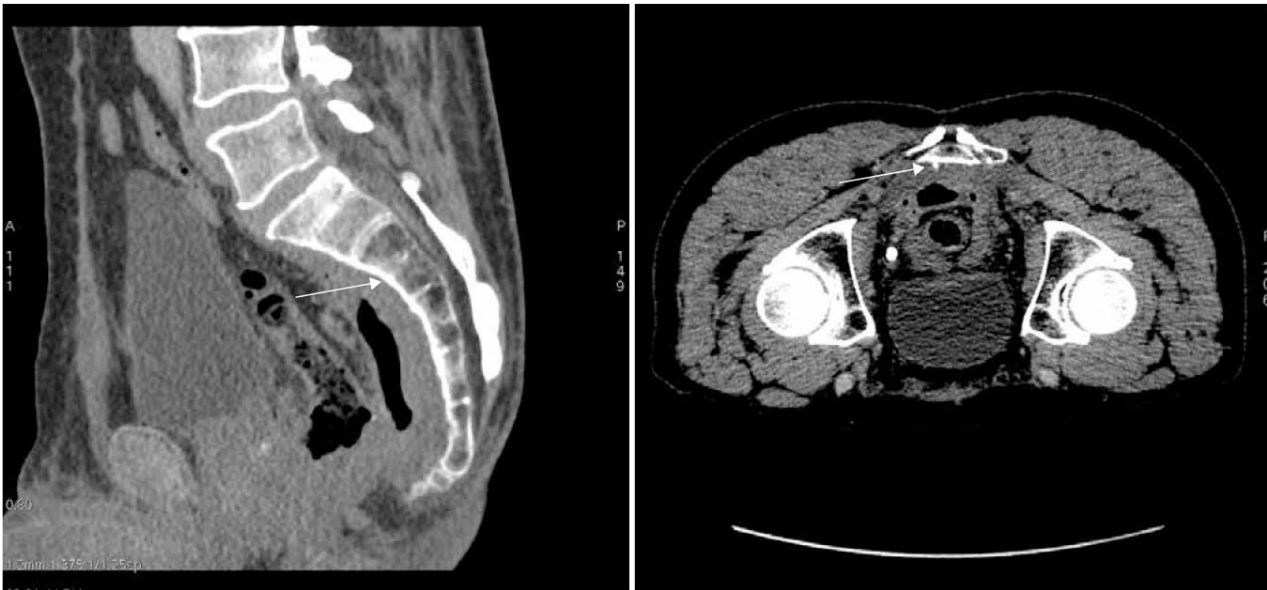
CT scan of the presacral area with abscess displayed (arrows)
